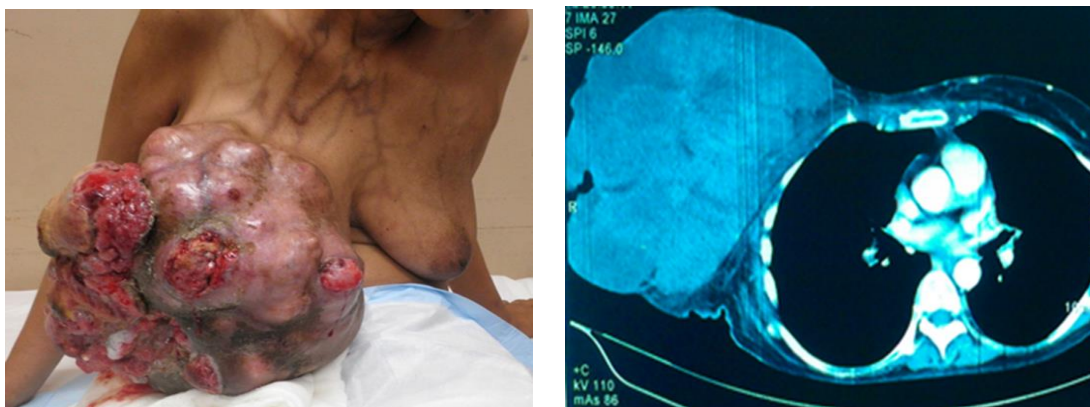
Giant phyllodes tumor with prominent dilated subcutaneous vessels; Figure 2 CT chest showing heterogeneous enhancing mass in right breast with ill-defined deep margin
